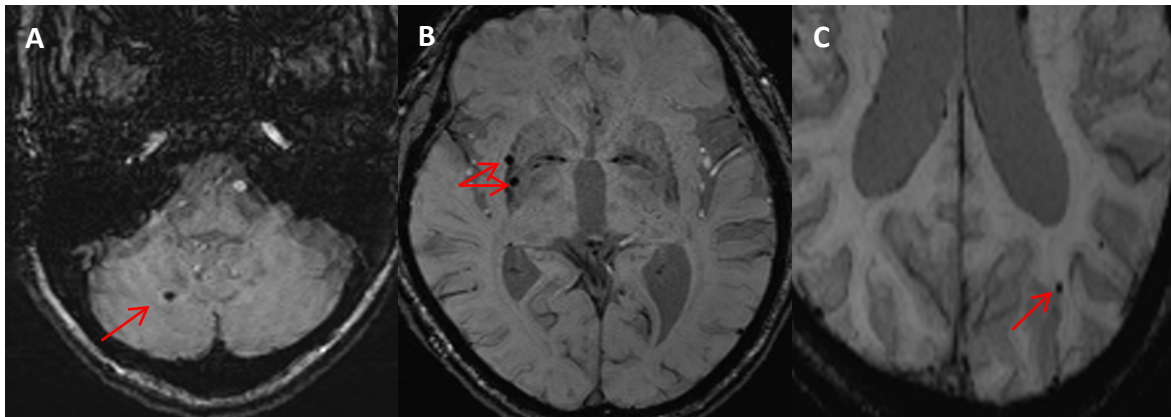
3: Markers of cerebrovascular diseases visually graded on MRI scans.
